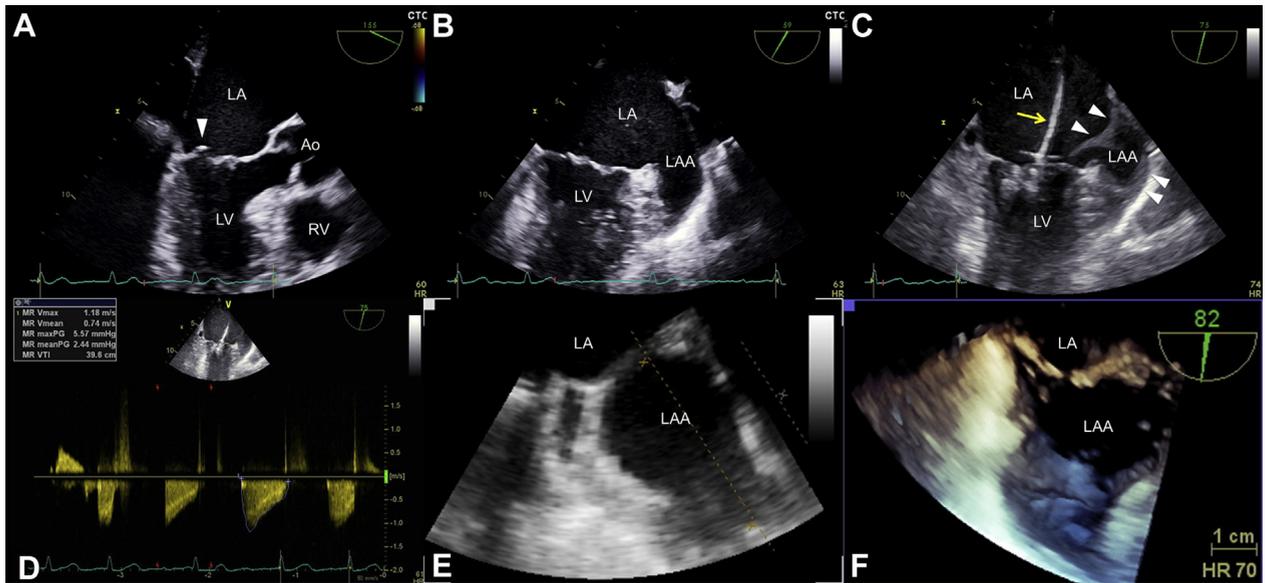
Transesophageal Echocardiographic Images of the Procedure
